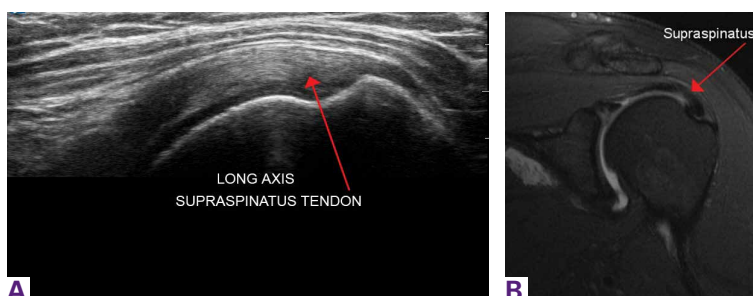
(A) Ultrasound image of left shoulder, long axis view. Normal supraspinatus tendon insertion onto the greater tuberosity. Red arrow indicates tendon. (B) Magnetic resonance imaging of left shoulder, coronal view. Normal supraspinatus tendon insertion onto the greater tuberosity. Red arrow indicates tendon.
